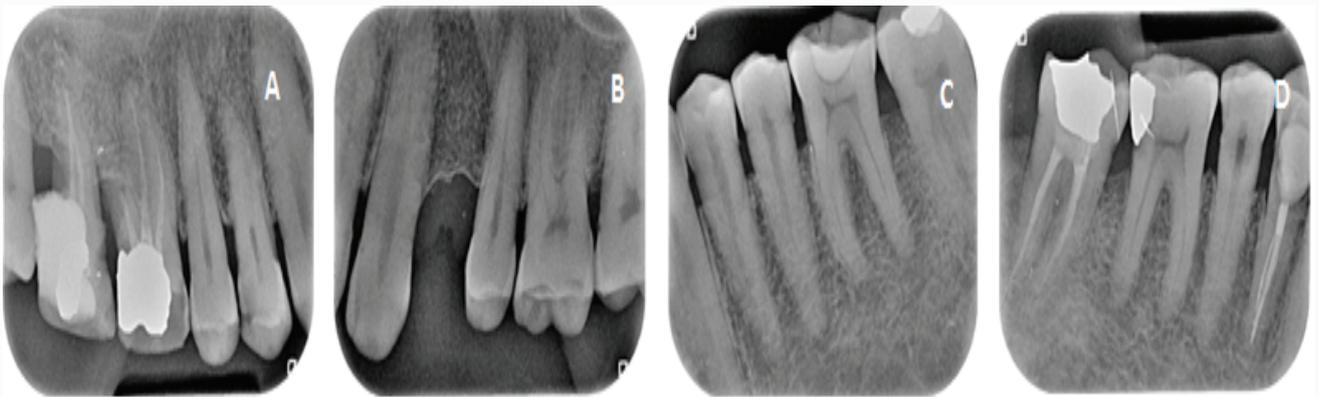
Intra-oral periapical radiographs showing interradicular space between the roots to determine locations for mini-screws insertion. A) Maxillary right side B) Maxillary left side C) Mandibular left side and D) Mandibular right side.
